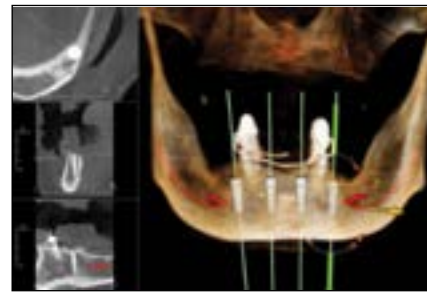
CBCT radiograph viewed in a dental implant software (Invivo [Anatomage]). Virtual implants were placed in positions for optimal bone volume surrounding the implants.
